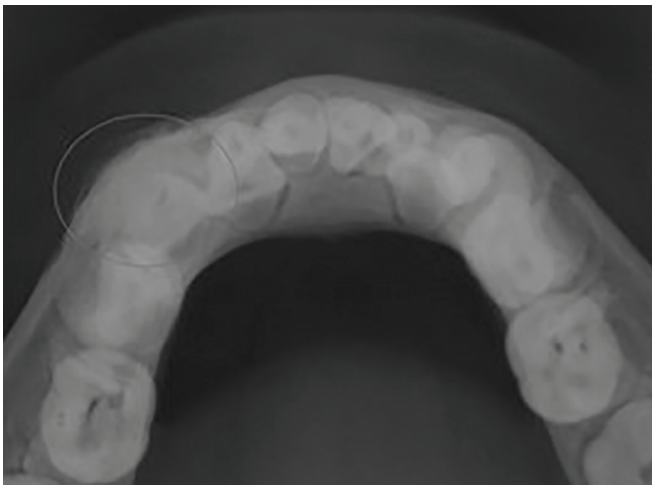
Mandibular occlusal radiograph showing radiopaque mass in the 83 region
